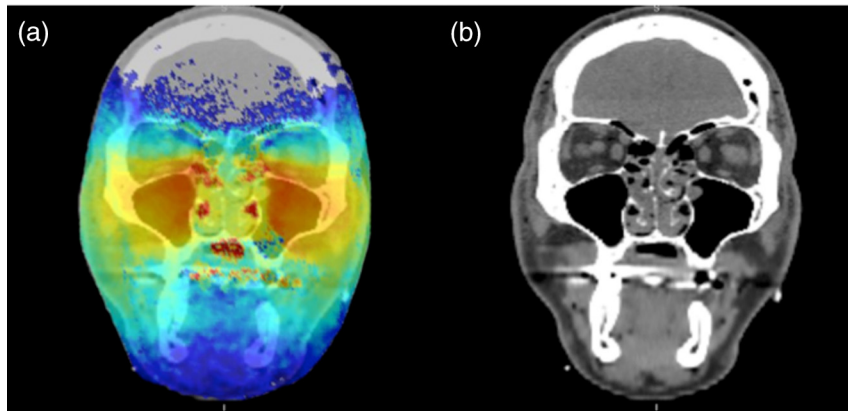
Overlay of the detected photon counts onto a coronal CT slice of patient #1 (a). The CT image alone is provided as a reference (b).
